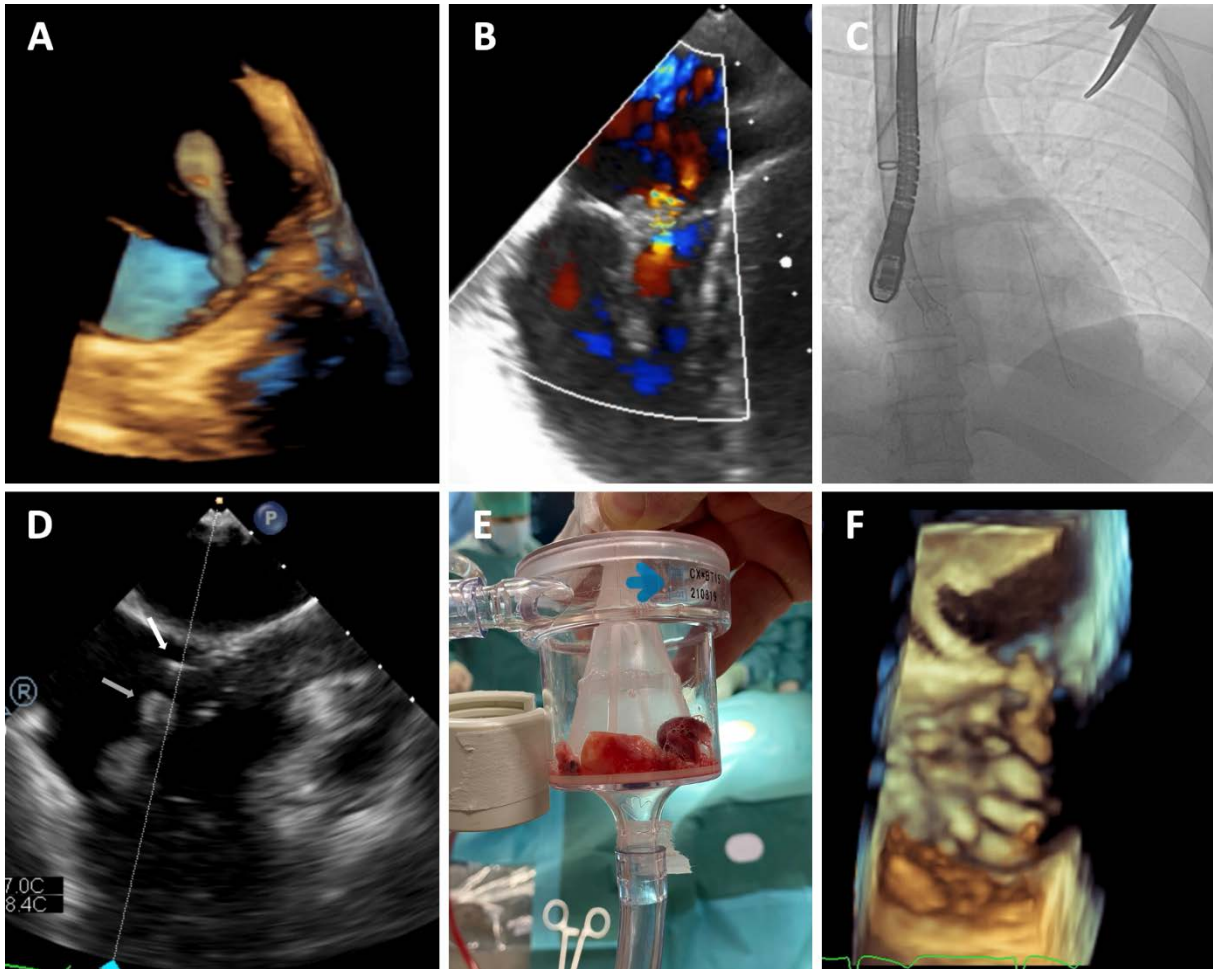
A. 3-D transesophageal echocardiography (TEE) shows a large vegetation attached to the anterior tricuspid leaflet — see Supplementary material, *Video S1*. B. TEE shows mild tricuspid regurgitation. C. The AngioVac drainage cannula is inserted into the right atrium, and the TEE probe is inserted into the esophagus — see Supplementary material, *Video S2*. D. The tip of the AngioVac cannula (white arrow) faces the vegetation (grey arrow) in the right atrium (TEE imaging) — see Supplementary material, *Video S3*. E. The vegetation material removed from the tricuspid valve is caught by the AngioVac filter. F. 3D TEE shows the tricuspid valve without vegetation
